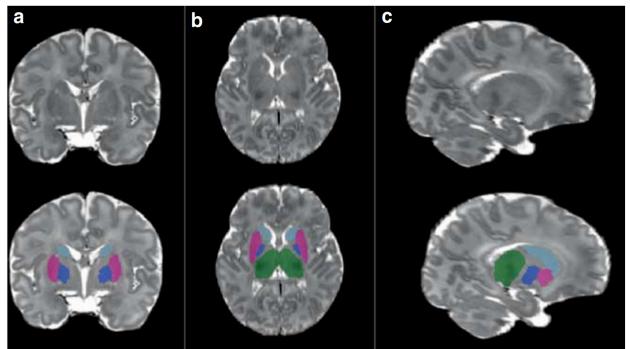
Image source: Loh et al., 2017.⁹⁴ Magnetic resonance images of basal ganglia and thalamus in (a) coronal, (b) axial, and (c) sagittal views. Light blue = caudate nucleus; dark blue = pallidum; fuchsia = putamen; green = thalamus.
